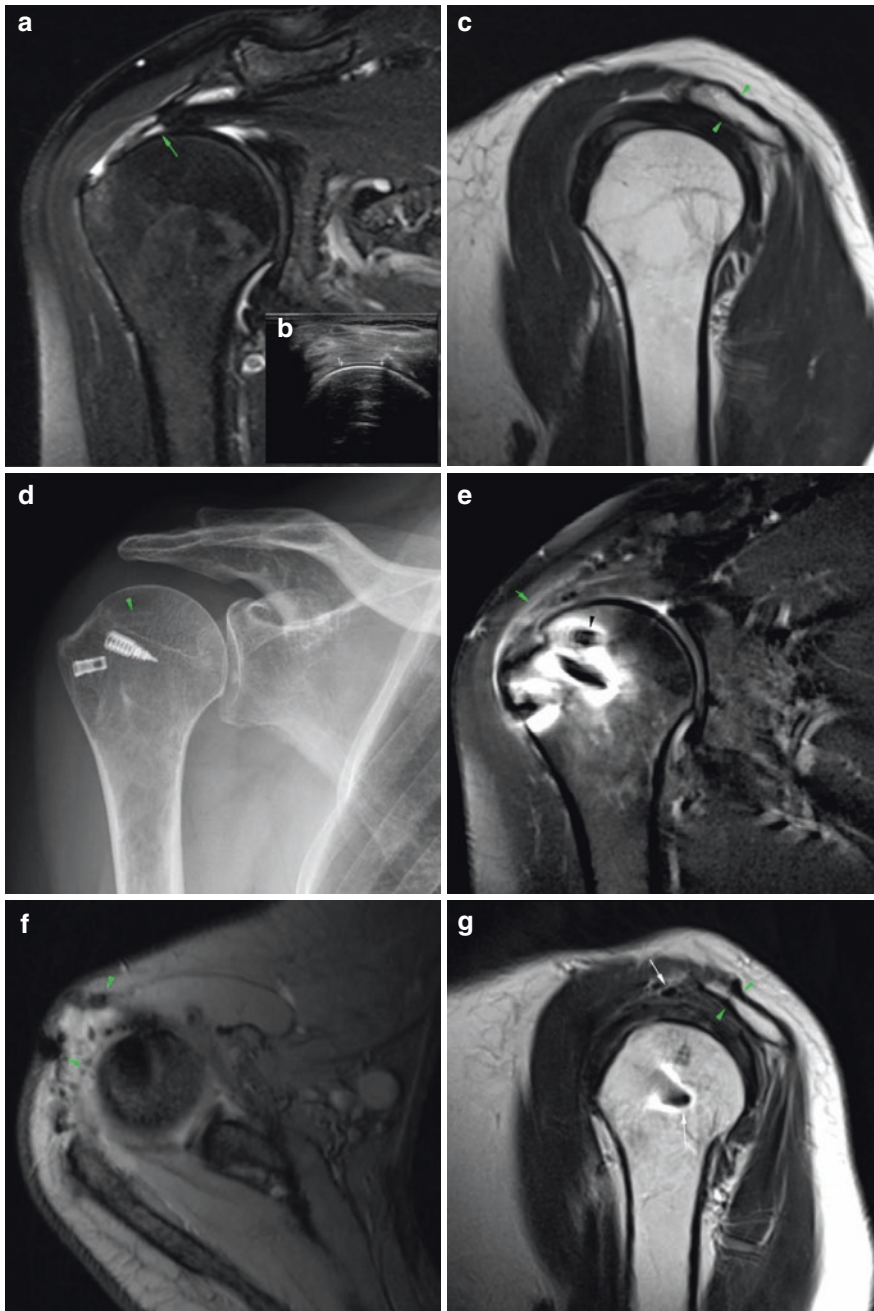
(a–g) Cuff repair follow-up, acromioplasty. (a) Preoperative T2-weighted FatSat coronal MR image. There is a full-thickness tear of the supraspinatus tendon with moderate retraction of the tendon (Patte stage 2). The tendon tear was also demonstrated on ultrasound (Insert b). (c) Preoperative T2-weighted sagittal MR image. Normal thickness of the acromion. (d) Frontal radiograph of the shoulder post supraspinatus tendon repair. There are two metal suture anchors and a nonmetal anchor (arrowhead). (e) Postoperative T2-weighted FatSat coronal MR image. The supraspinatus tendon has been
